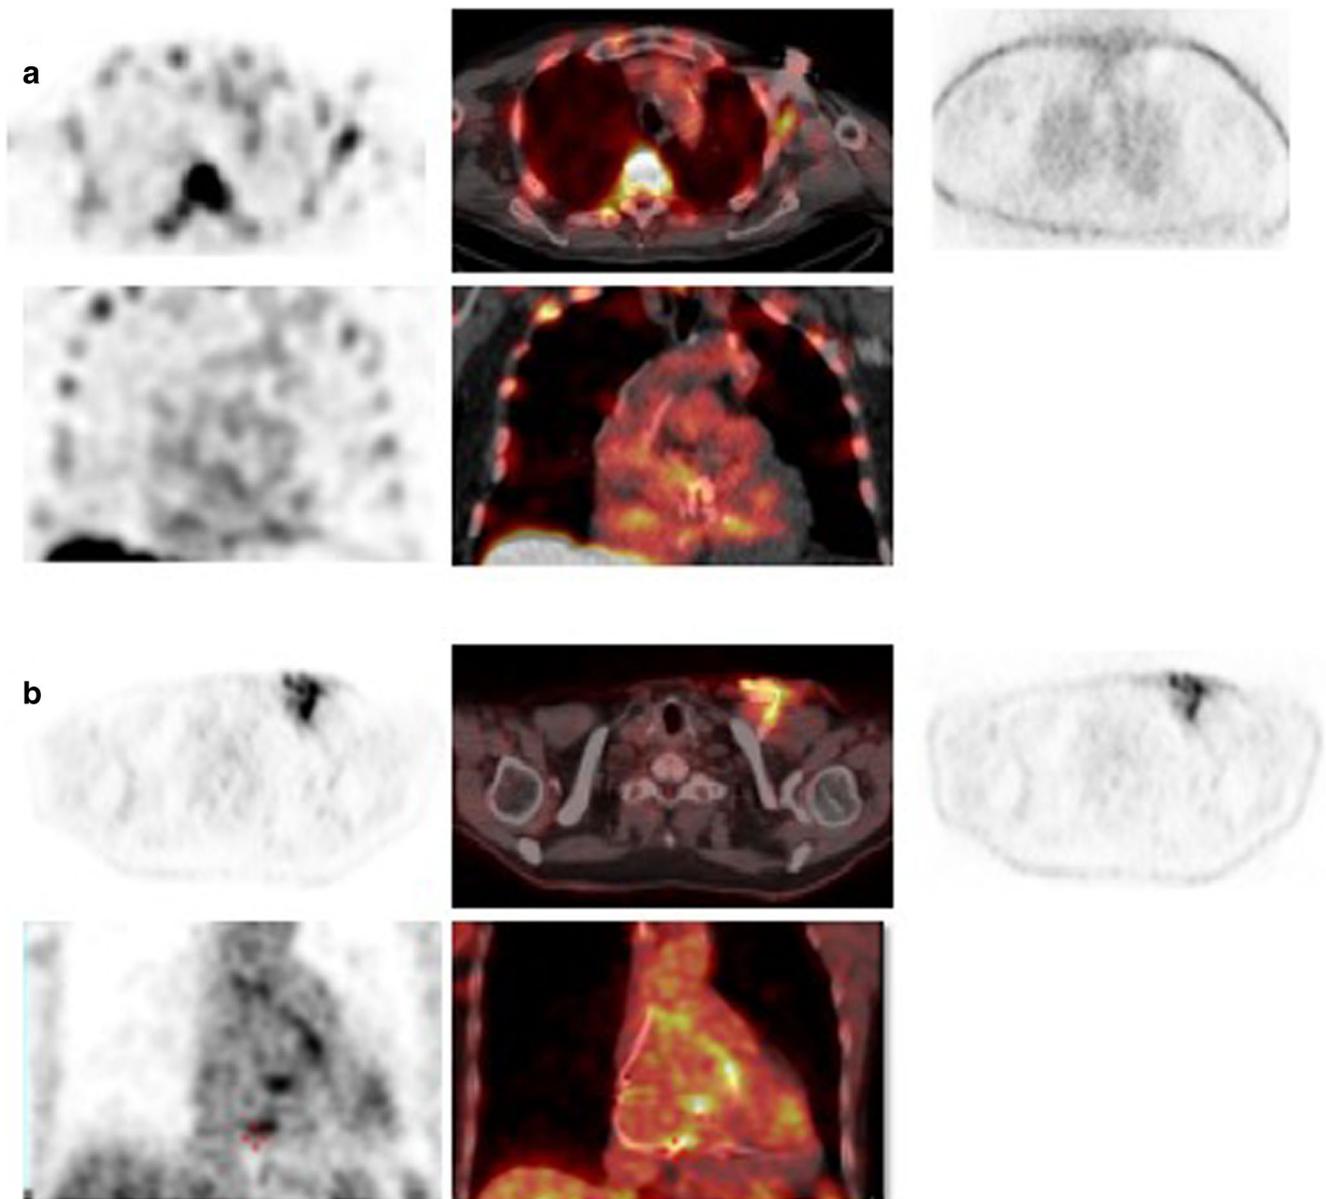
^{99m}Tc -HMPAO WBC (a) and ^{18}F FDG PET/CT (b) in patients with CIED infection. Faint WBC uptake is present at the pocket site which is an artifact due to attenuation correction as demonstrated by the disappearance of the uptake at the non-attenuated corrected images (a upper panel from left to right transaxial emission, superimposed SPECT/CT and non-attenuated corrected), whereas the uptake at the intracardiac portion of the leads, is consistent with infection (lower panel, coronal view emission and fused SPECT/CT). In b increased
